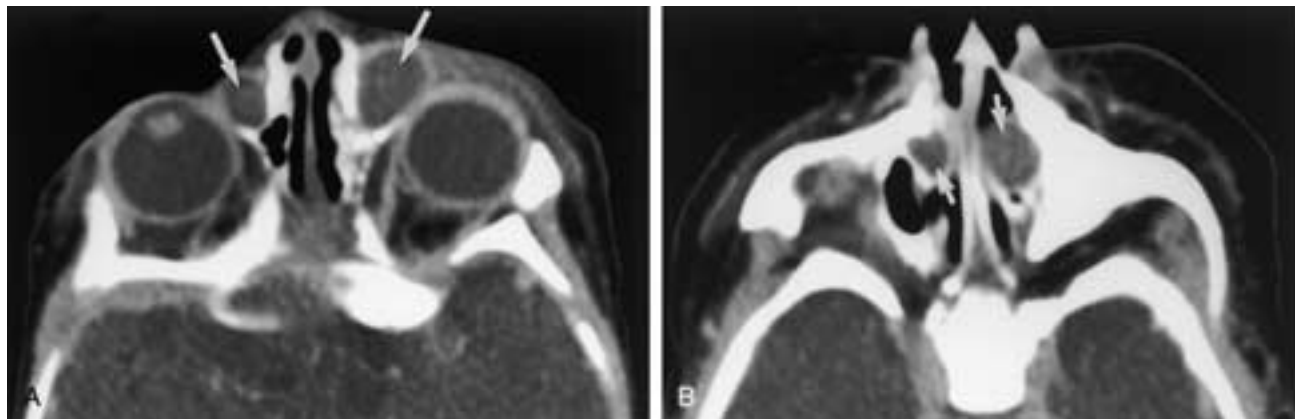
Bilateral nasolacrimal duct (NLD) cysts in a 4-day-old girl. Contrast-enhanced axial CT (soft-tissue windows) shows (A) dilated low attenuation and mildly ring-enhancing nasolacrimal sacs (arrows) and (B) NLD cysts (arrows).
